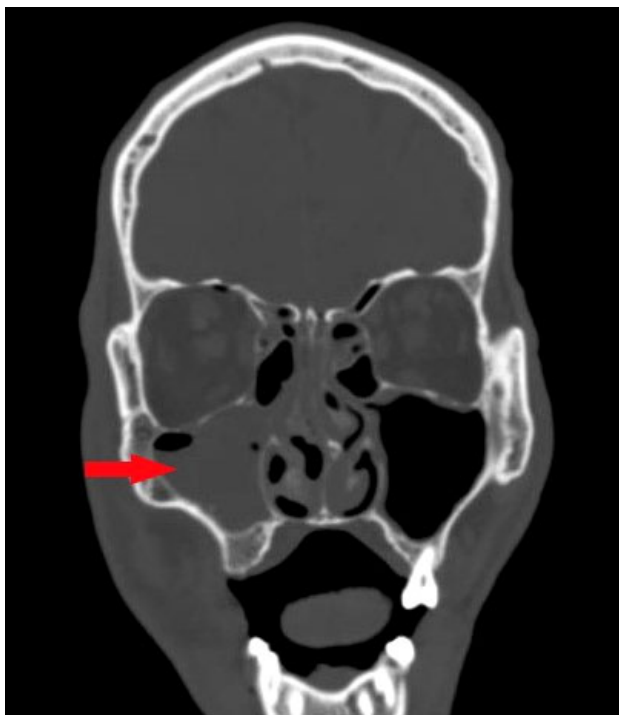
CT of head (coronal view). Decreased maxillary sinus pneumatization on the right in a patient with ACTT
